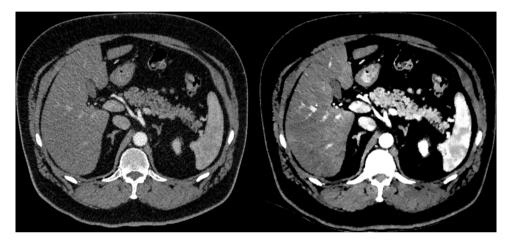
MRI images of pancreatic steatosis.
